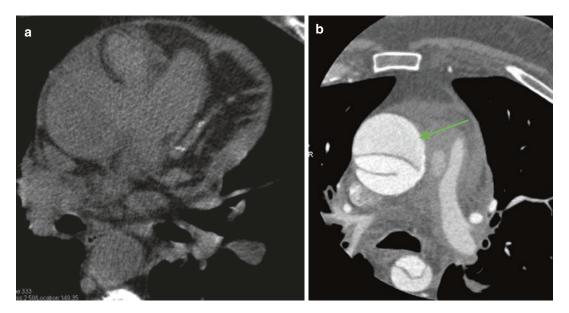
(a) Axial view of the noncontrast calcium score image demonstrates loss of tissue distinction between the aortic root and main pulmonary artery with higher density material. In addition, there is a small pericardial effusion seen. (b) Coronary CTA examination confirms A Type-A aortic dissection with an intimal flap seen
